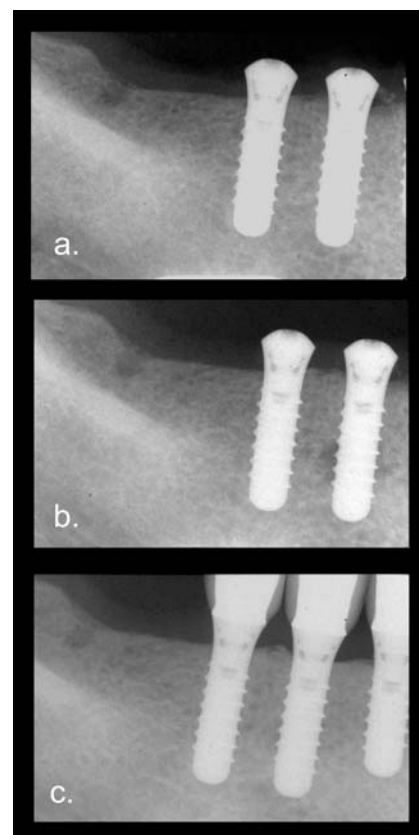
Patient GA, a 51-year-old woman. (a) Three implants were placed in the lower-right sextant. (b) At 1-month postoperatively, a radiograph disclosed a radiolucency located midlevel of the root, and the patient remained symptom free. (c) No specific treatment was initiated, and the lesion disappeared spontaneously after 8 months.
